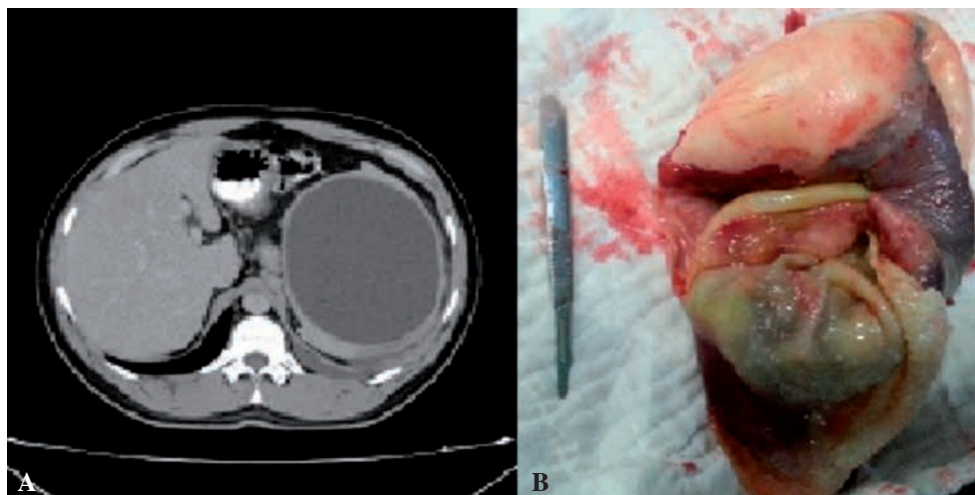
Large homogeneous splenic cystic lesion measuring 160 × 110 mm, with no septa was detected by abdominal computed tomography scan (A). Non-lobule splenic giant cyst, protrude from the splenic parenchyma with thin rim (B).
